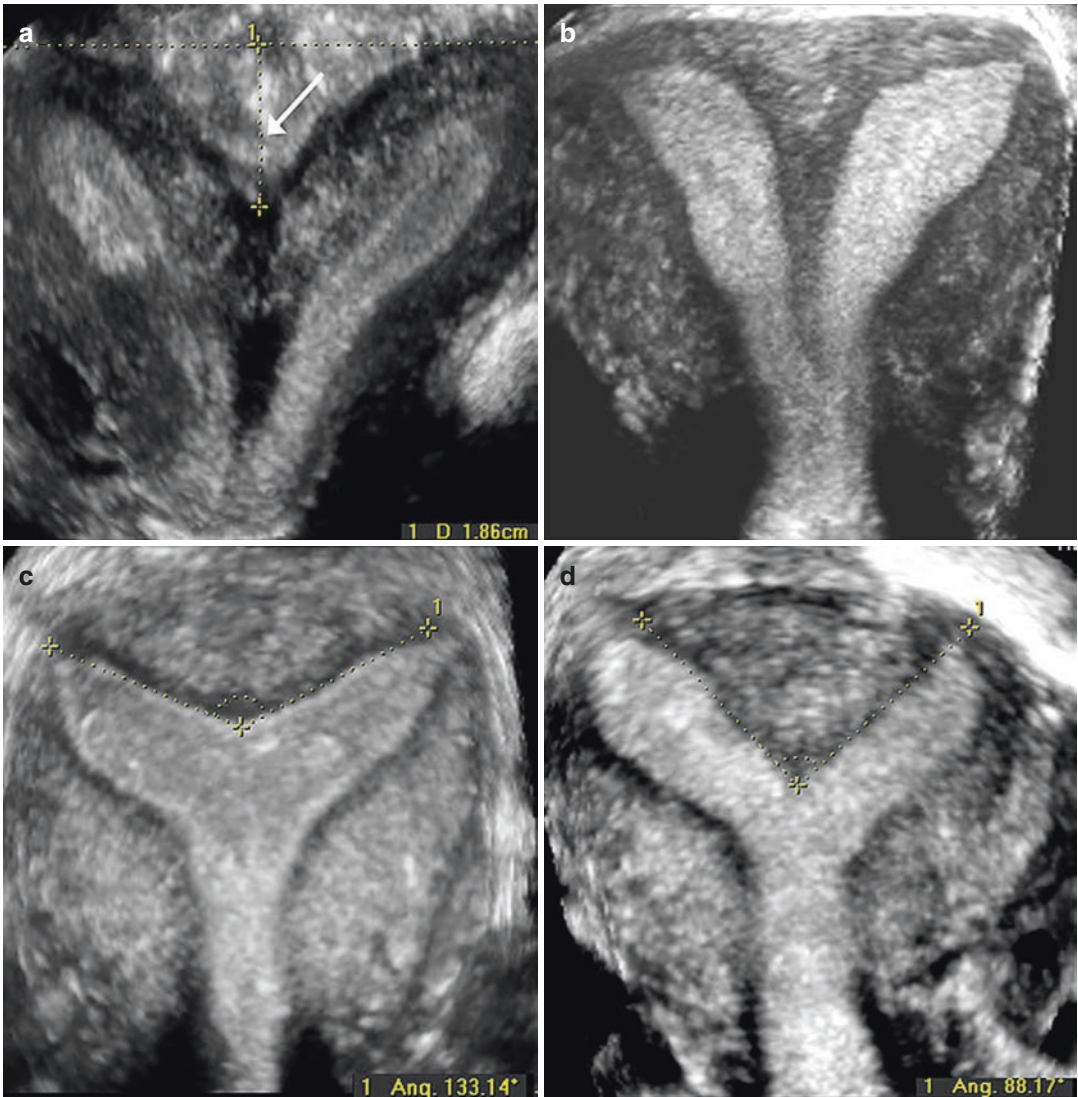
Three-dimensional rendered coronal ultrasound images demonstrating ultrasound criteria for classification of congenital uterine anomalies. (a) Bicornuate uterus: two divergent cornua are noted, divided by a sagittal cleft >10 mm (*arrow*). (b) Complete septate uterus: a normal external uterine contour is present, and a septum divides the endometrial cavity and extends to the cervix. (c) Arcuate
